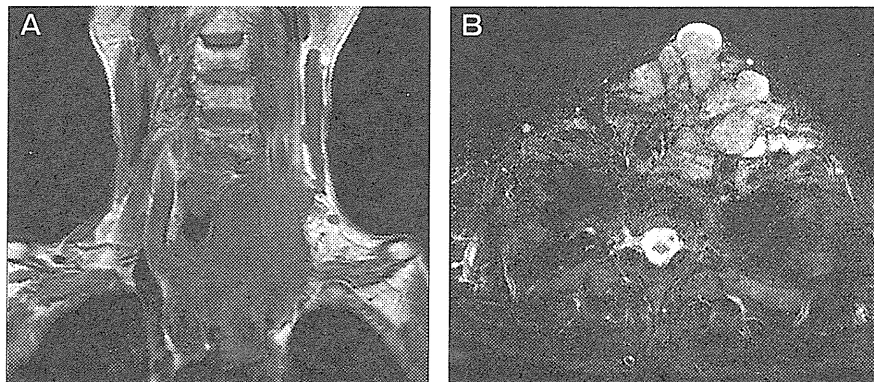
(A) T1-weighted MRI image shows a tumor iso-intense with the muscle in the anterior neck; tumor infiltration of the left sternocleidomastoid muscle and left internal carotid vein was suspected. (B) A fat-suppression (short TI inversion recovery) T2-weighted image reveals the fibrous septum as a low-intensity area in the tumor.
